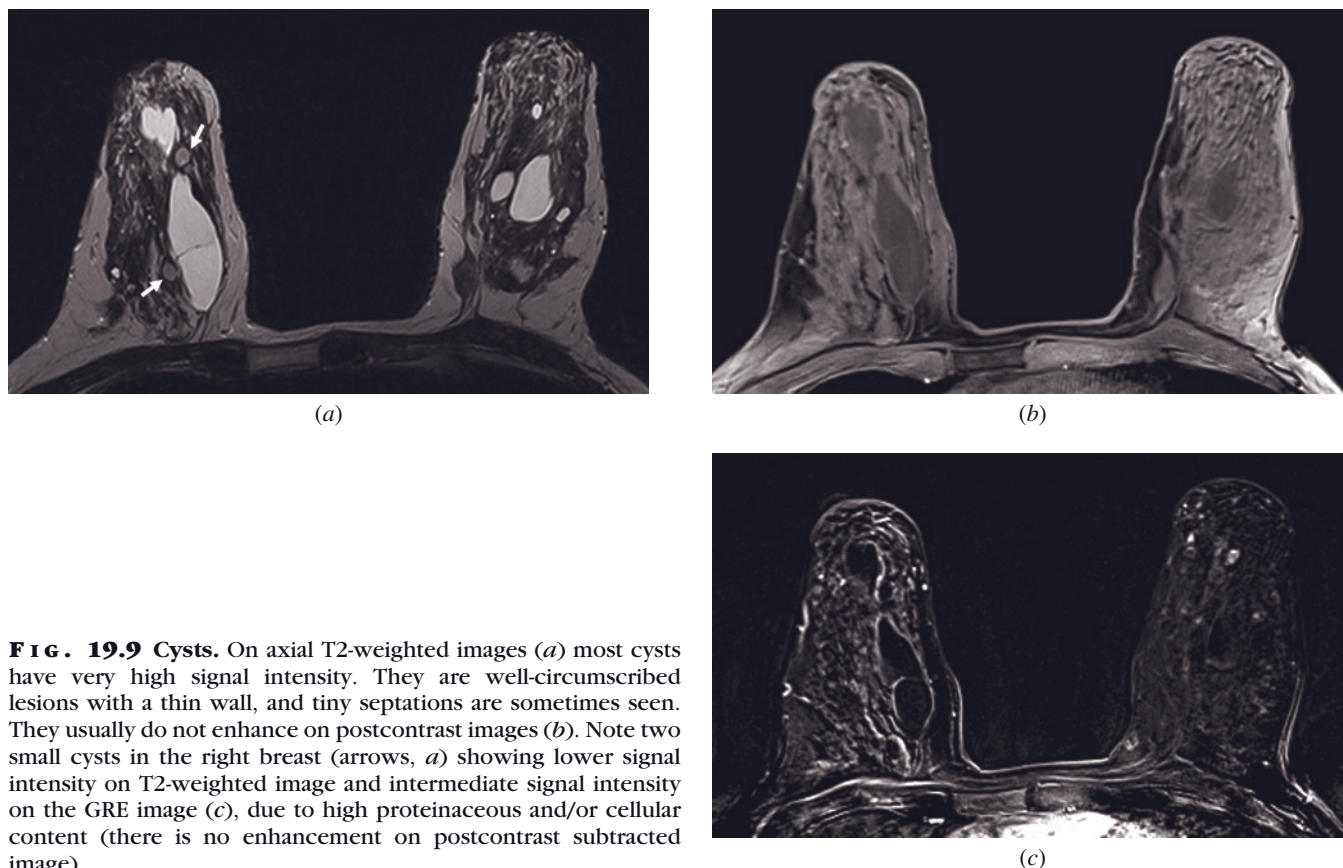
Cysts. On axial T2-weighted images (a) most cysts have very high signal intensity. They are well-circumscribed lesions with a thin wall, and tiny septations are sometimes seen. They usually do not enhance on postcontrast images (b). Note two small cysts in the right breast (arrows, a) showing lower signal intensity on T2-weighted image and intermediate signal intensity on the GRE image (c), due to high proteinaceous and/or cellular content (there is no enhancement on postcontrast subtracted image).
